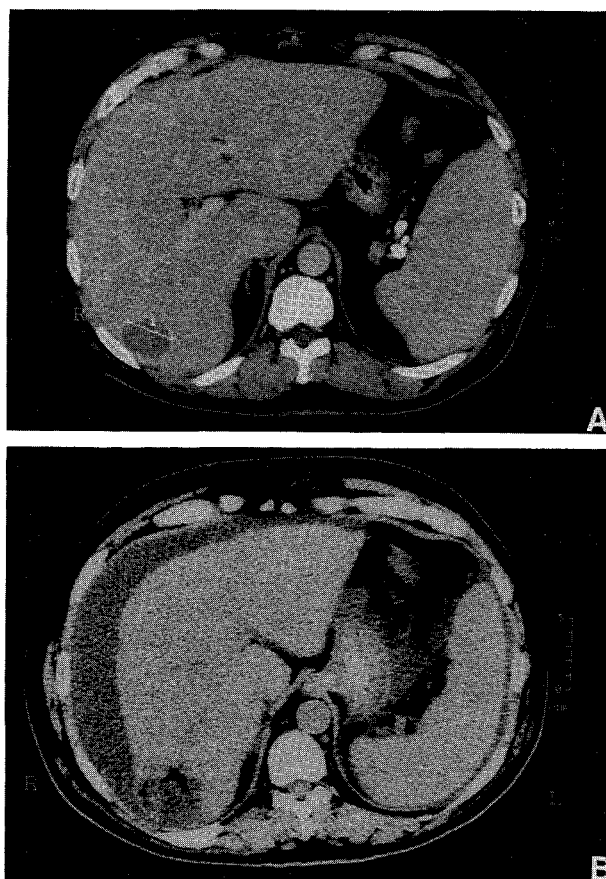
Contrast enhanced computed tomography (CT) showing splenomegaly and a 40 mm tumor of hepatic segment VI before treatment (A). Unenhanced CT performed 3 weeks after the second percutaneous acetic acid injection session showing ascites and an area of low attenuation with gas at tumoral site.
